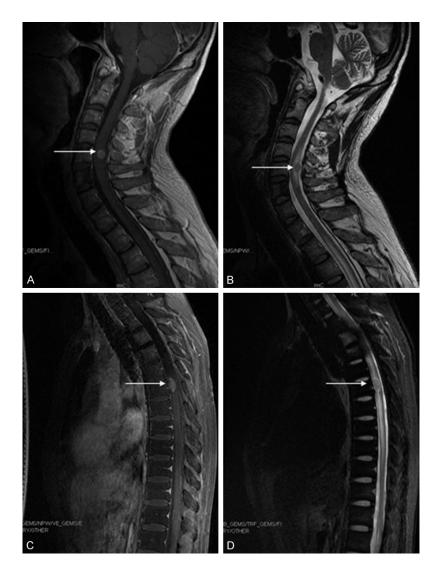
The results of MRI of the cervical and thoracic spine. Magnetic resonance imaging (MRI) of the cervical and thoracic spine demonstrates heterogeneous increased signal intensity in spinal cord and the central canal expansion expansion, consistent with intramedullary spinal cord metastases. A. MRI of the cervical spine with T1-weighted image demonstrates a solitary enhancing intramedullary nodular lesion at C5 level (arrow); B. T2-weighted image shows a solitary intramedullary nodular lesion at the same level as in A with expansion of the upper and lower spinal cord (arrow); C. MRI of the thoracic spine with T1-weighted image demonstrates a solitary nodular lesion at T6 level (arrow); D. T2-weighted image demonstrates a size of 2.0 cm×0.9 cm solitary enhancing intramedullary nodular lesion at the same level as in C (arrow).
